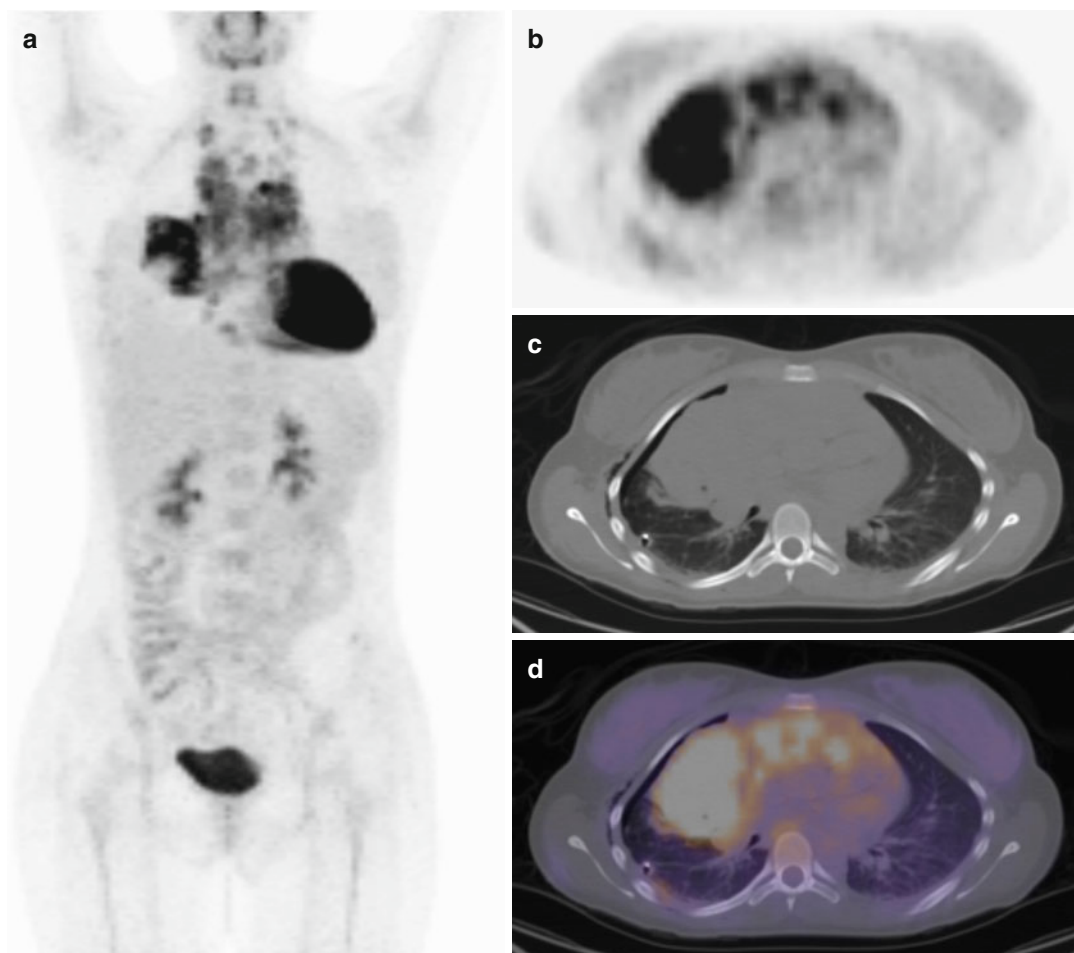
^{18}F -FDG PET/CT to evaluate advanced stage Hodgkin's disease. (a) In a 17-year-old female with stage IV nodular sclerosing classic Hodgkin's disease, the MIP of an FDG-PET shows widespread disease involvement in the chest that is further characterized with PET/CT. (b) Transaxial ^{18}F -FDG PET image shows extensive FDG-avid disease in the mediastinum and in the right hemithorax.
